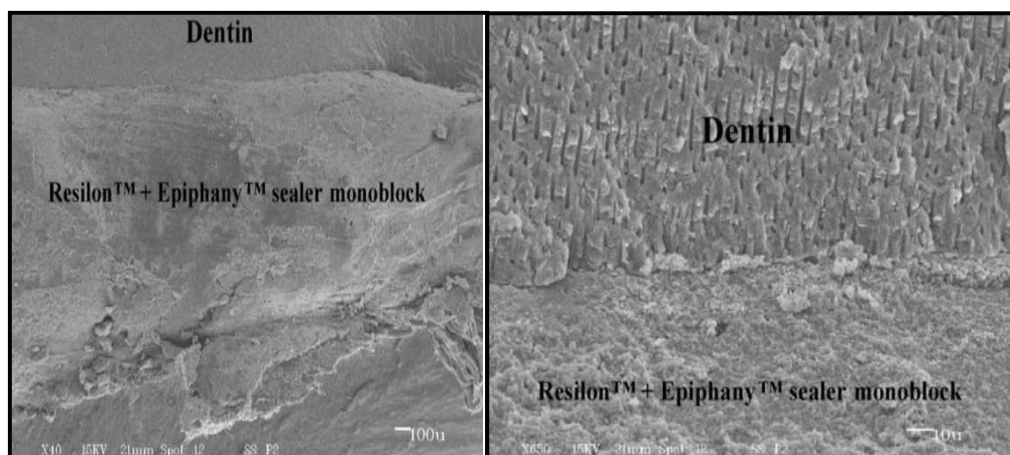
a: SEM view at "low" magnification showing the intimate shape of Resilon® cone (Resilon Research, Madison, CT), canal wall, and Epiphany/Resilon® (Resilon Research, Madison, CT).
